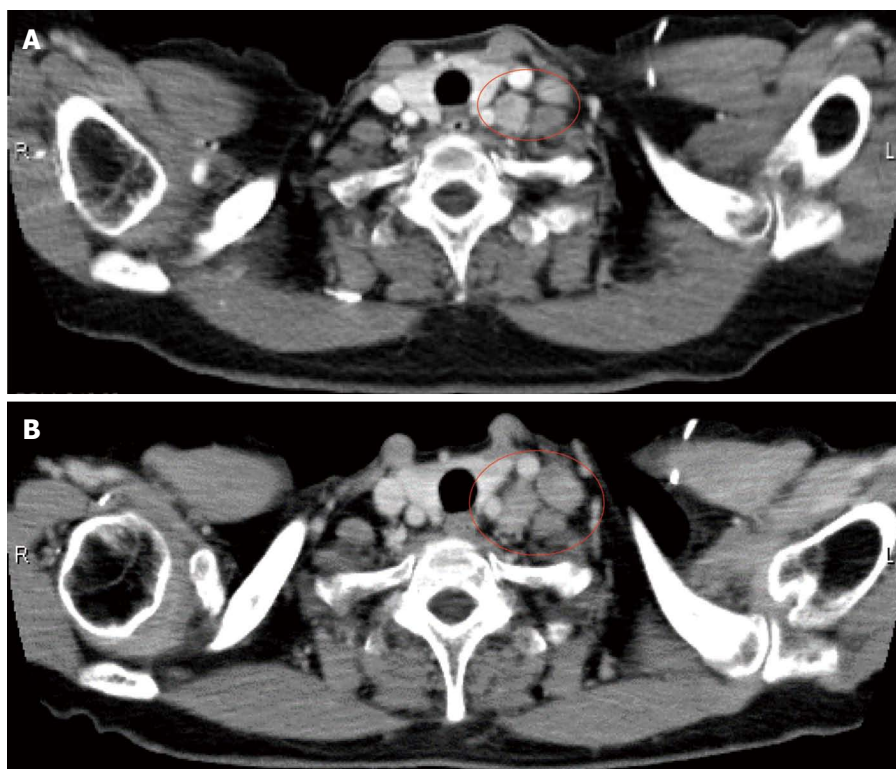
Computed tomography detected two swelling 12 mm of lymph nodes at the left supraclavicular (A); and Virchow lymph nodes had slowly grown up to 17 mm (B).
